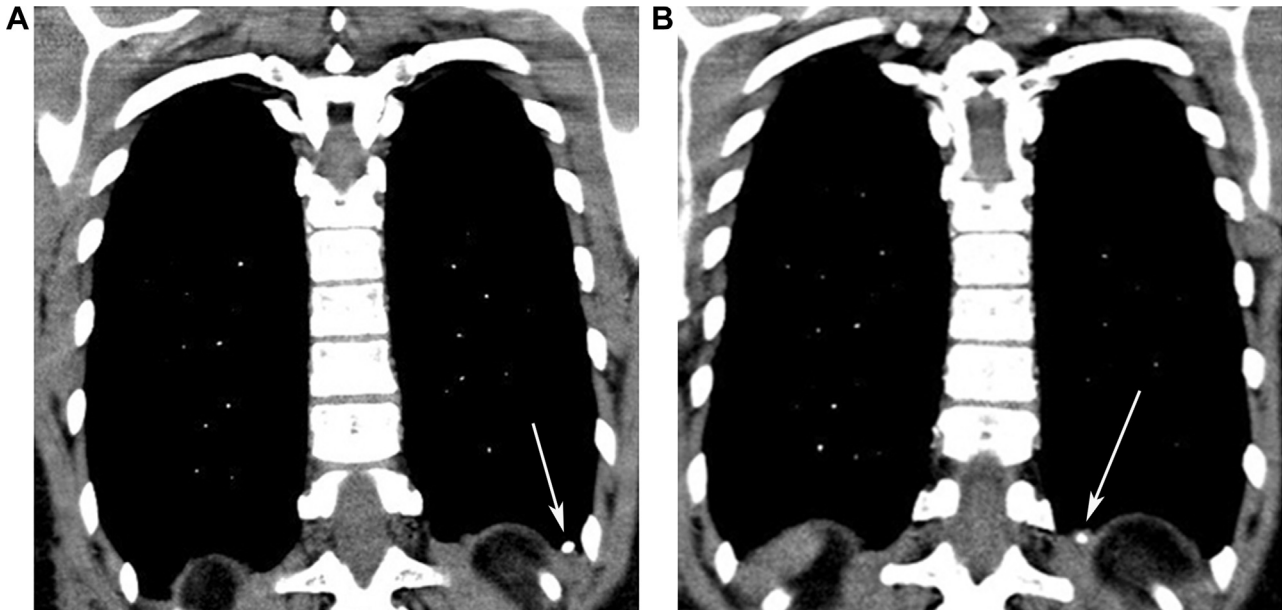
An asymptomatic 50-year-old man with thoracolithiasis. A. Initial coronal chest computed tomography shows a calcified nodule at the left costophrenic angle (arrow). B. A second chest computed tomography examination shows medial movement of the nodule (arrow).
